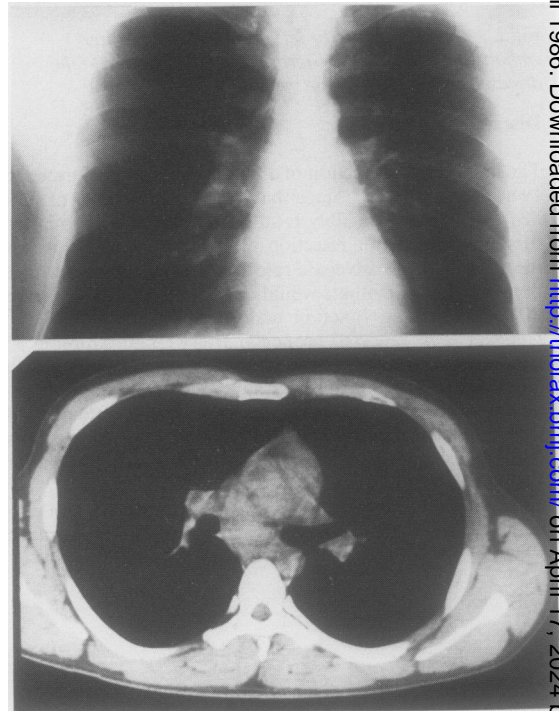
Chest radiograph and computed tomogram nearly five months after transcarinal needle aspiration, showing appreciable decrease in the size of the bronchogenic cyst.
